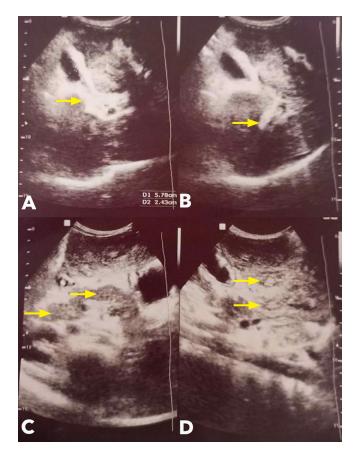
Liver ultrasound of the patient prior to treatment with praziquantel. There are hyperechoic bands of fibrosis along the portal vein branches (A and B, arrows). The liver parenchyma demonstrates mosaic pattern seen in cases of schistosomiasis (C, arrows). Note the multiple isoechoic nodules with hypoechoic rim within the liver parenchyma (D, arrows). (Photo courtesy of the patient's family, reproduced with consent).
